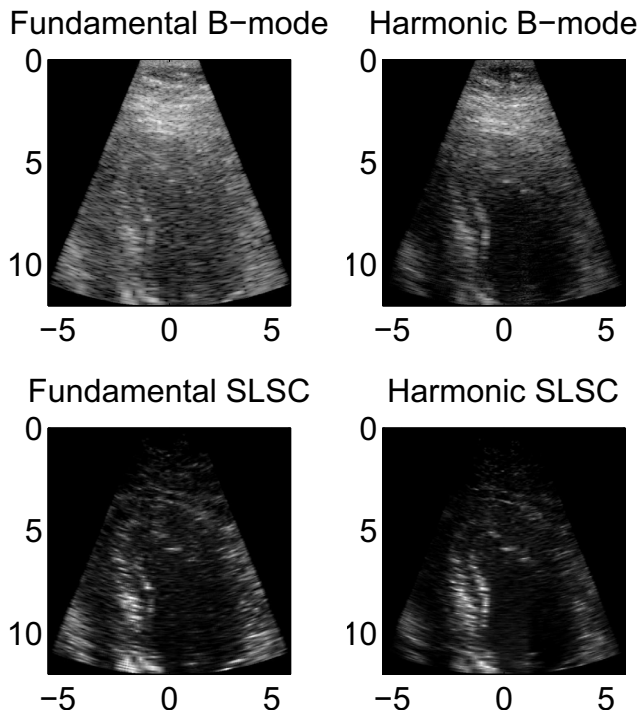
Apical four-chamber views of the left ventricle of Volunteer 10.
